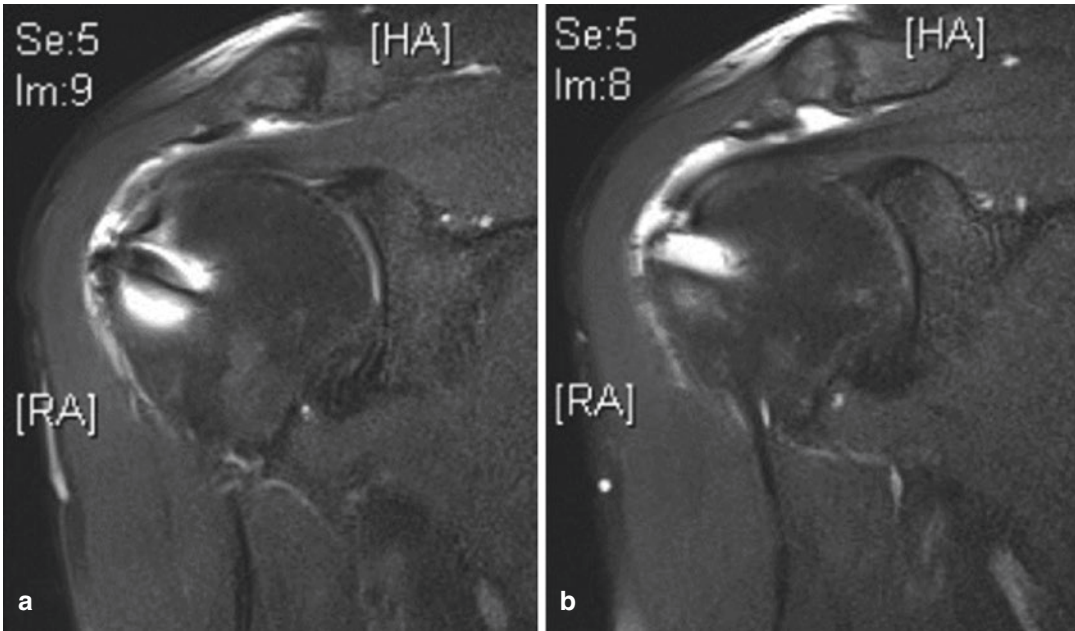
(a, b) MR images (coronal views) 6 months after primary repair; a clear space between the anchor and the lateral border of the tendon is visible
